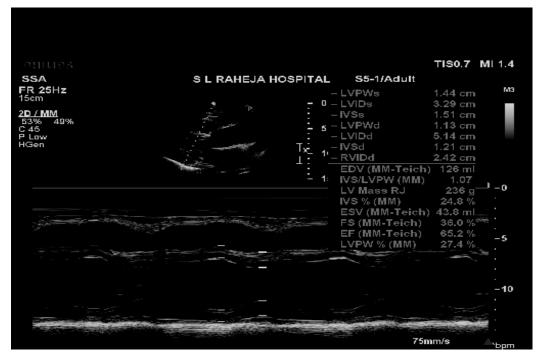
sample echocardiogram showing a 4-chamber view and the cross section of the left ventricle
